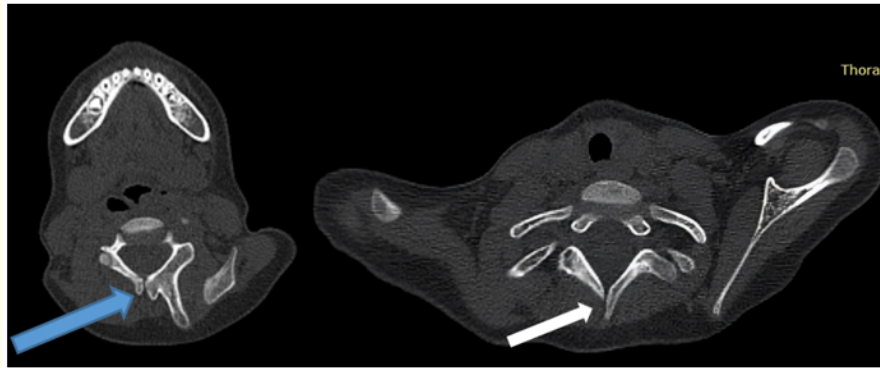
Axial cervicothoracic CT scan, showing associated vertebral abnormalities.
